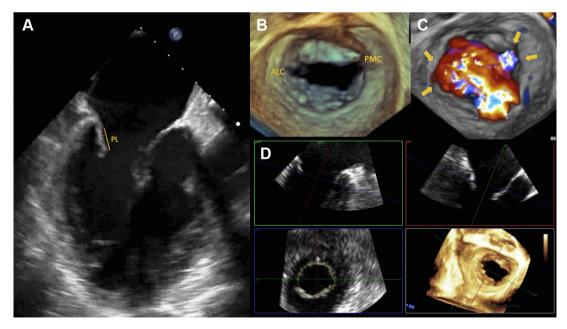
Echocardiographic features of suboptimal residual mitral regurgitation. (A) Posterior leaflet (PL) length in mid-diastole. (B) 3-dimensional reconstruction of the mitral valve. (C) Arrows indicating the presence of bicommissural mitral regurgitation. (D) Multiplanar reconstruction planes with measurement of mitral valve area. ALC, anterolateral commissure; PMC, posteromedial commissure.
